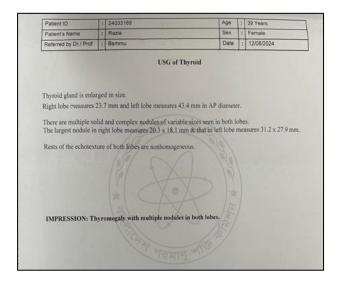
The ultrasonogram findings of the patient.
